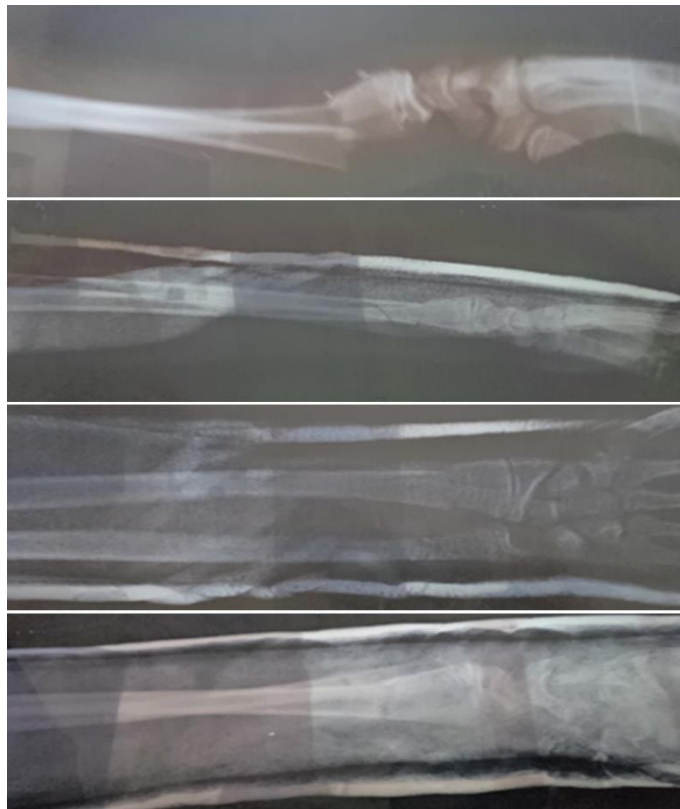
Pre and postreduction X-Ray of distal BB forearm fracture and follow-up view shows callus with good position.
